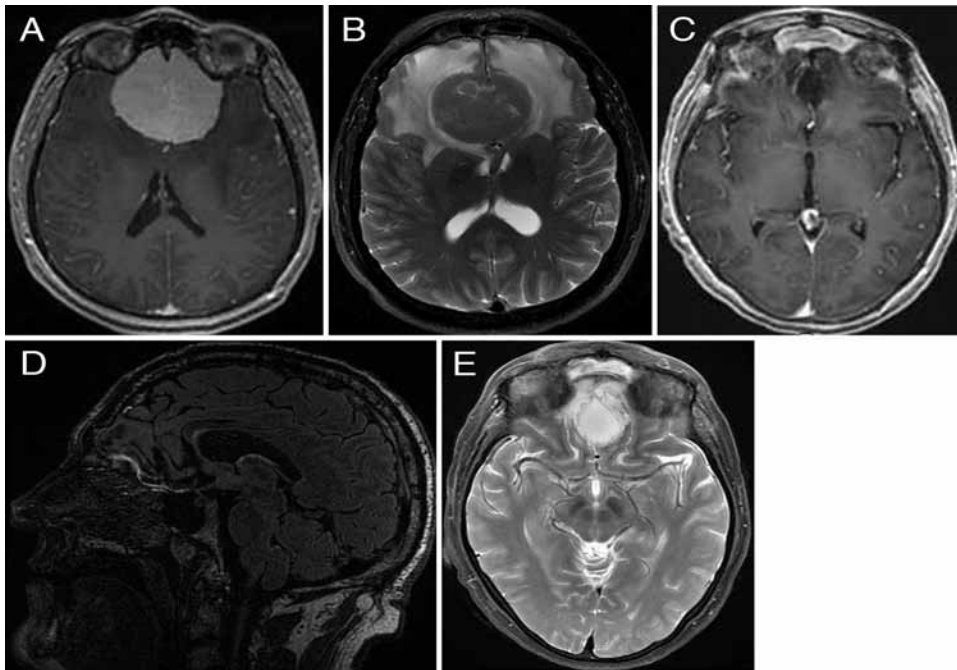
Case 3. A and B: Preoperative T1-weighted postcontrast axial (A) and T2-weighted axial (B) MR images showing a very large meningioma of the ACF associated with extensive vasogenic edema. The meningioma extends toward the tuberculum/diaphragma sellae. C–E: Images obtained 2 years postoperatively. Postcontrast axial T1-weighted MR image (C). There are almost no residual T2 signal changes on T2-weighted FLAIR sagittal (D) and T2-weighted axial (E) MR images.
